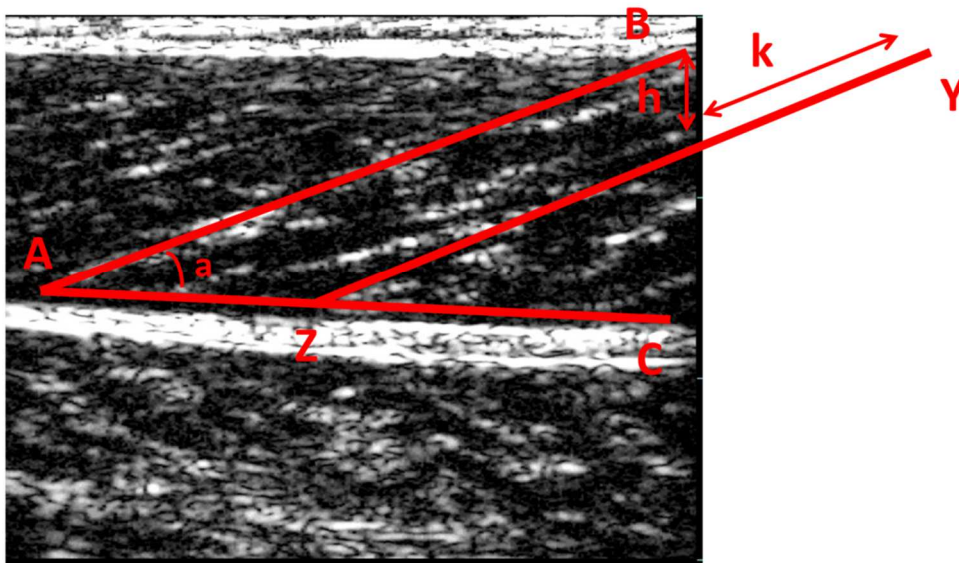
Fascicle length and pennation angle measurements from MG muscle. Fascicle length A to B and angle A between B and C were analyzed manually from the US sonograms. In case fiber did not fit to a sonogram (Z to Y) length of k was estimated using the length h.
